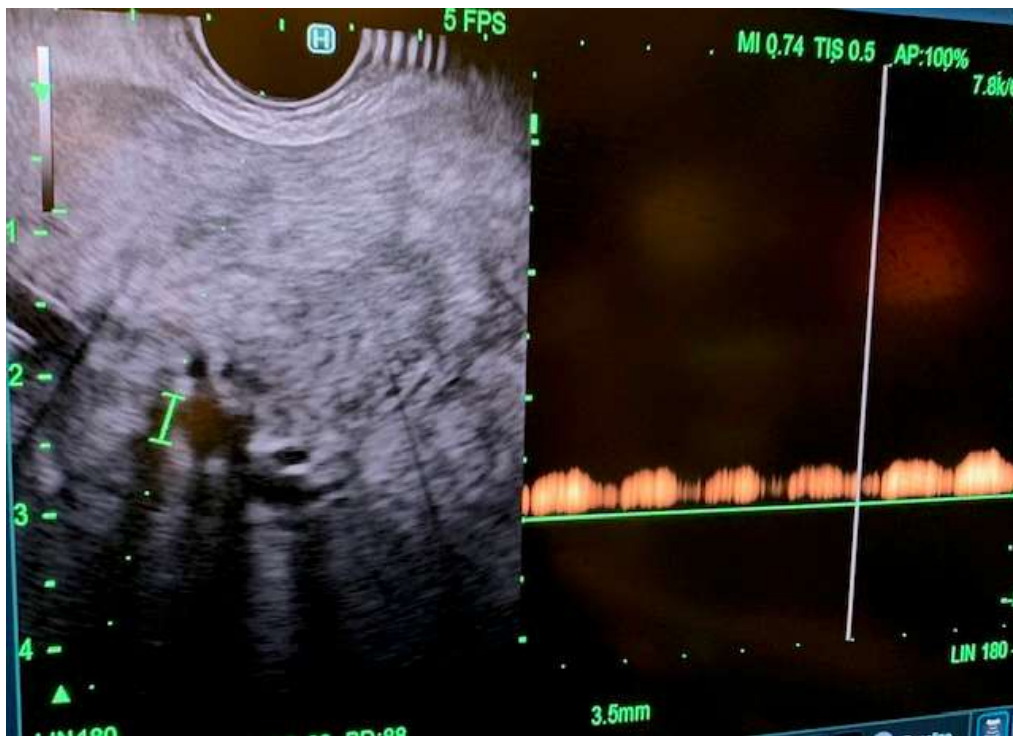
Pulse wave Doppler of left portal vein prior to manometry.
